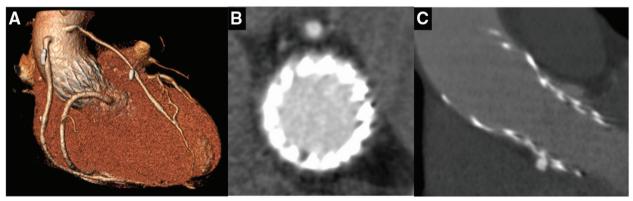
(A) Postoperative coronary CT revealed good blood flow from the SVGs to the coronary arteries. (B and C) Owing to the overlapping stent frames and occlusion of the sinus of Valsalva, cannulation of the coronary arteries was considered impractical. SVGs: saphenous vein grafts
